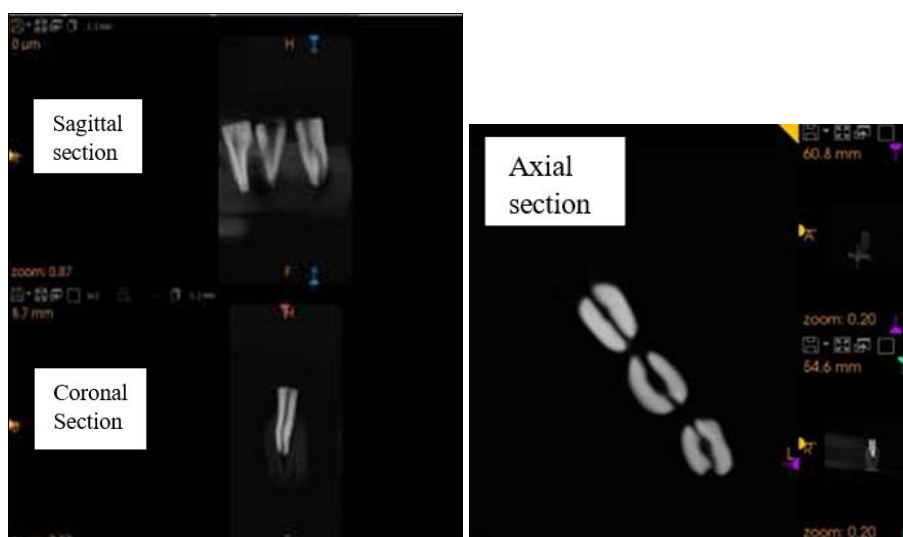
CBCT images of Samples
